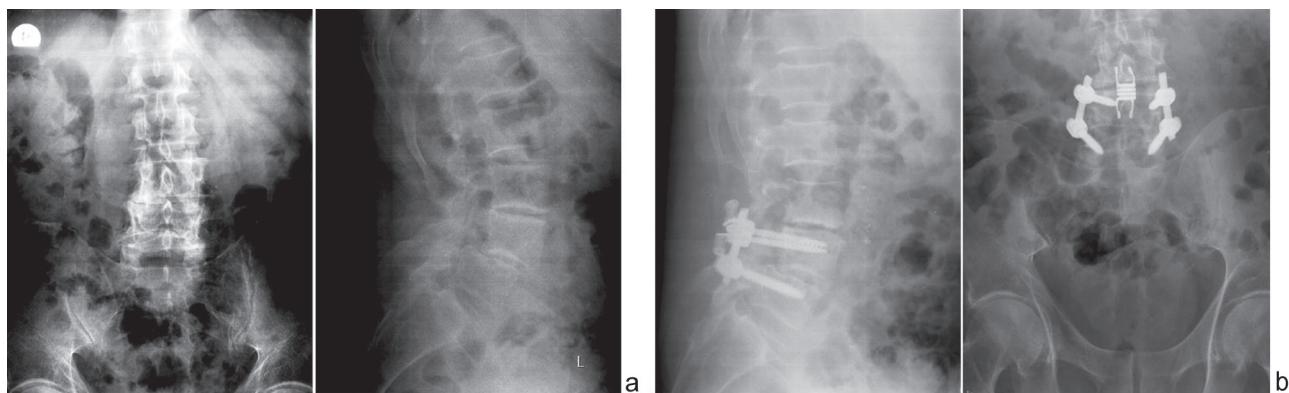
Radiographs of the spine of a 62-year-old patient K. showing (a) unstable grade I spondylolisthesis of L4, degenerative subcompensated spinal stenosis at L4-L5 level on preoperative AP and lateral views (b) bilateral decompression interlamin(facet)ectomy at L3-L4, L4-L5 level, transpedicular fixation of the spine, posterolateral spondylodesis at L4-L5 level using bone autograft, dynamic stabilisation of L3-L4 segment with interlaminar implant at 3-year follow-up
